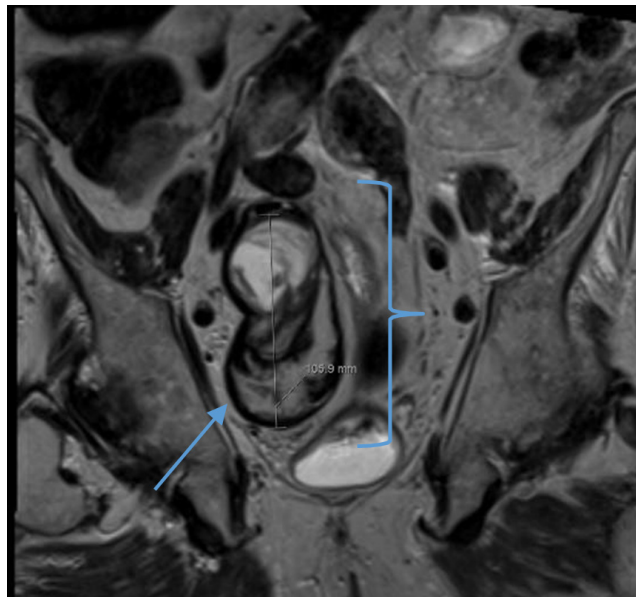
MRI Pelvis T2 Coronal. Image showed aneurysm (arrow) exerting mass effect (bracket) on the right lumbosacral trunk L3, L4, L5, and S1 nerve.
